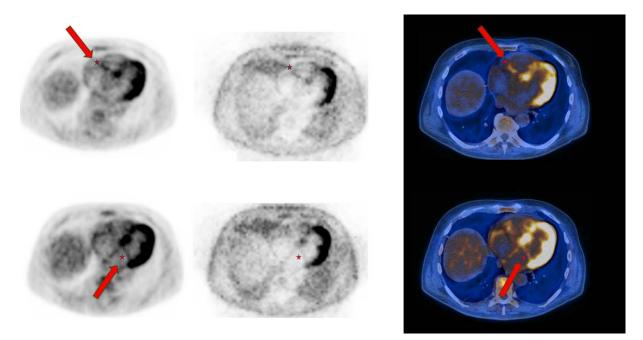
A. Axial ¹⁸F-FDG PET/CT scans. Physiological tracer uptake in the myocardium - scan for oncological indications without dietary myocardial suppression. There is also a visible accumulation of tracer in the muscle of both atria as an expression of their overload. Upper row: apparent pathological focal tracer uptake at the native tricuspid valve site (indicated by an arrow and red asterisk). Lower row: faint uptake at the mitral valve site. From left to right: axial PET images with attenuation correction, axial PET images without attenuation correction (NAC), hybrid axial PET-CT scan
